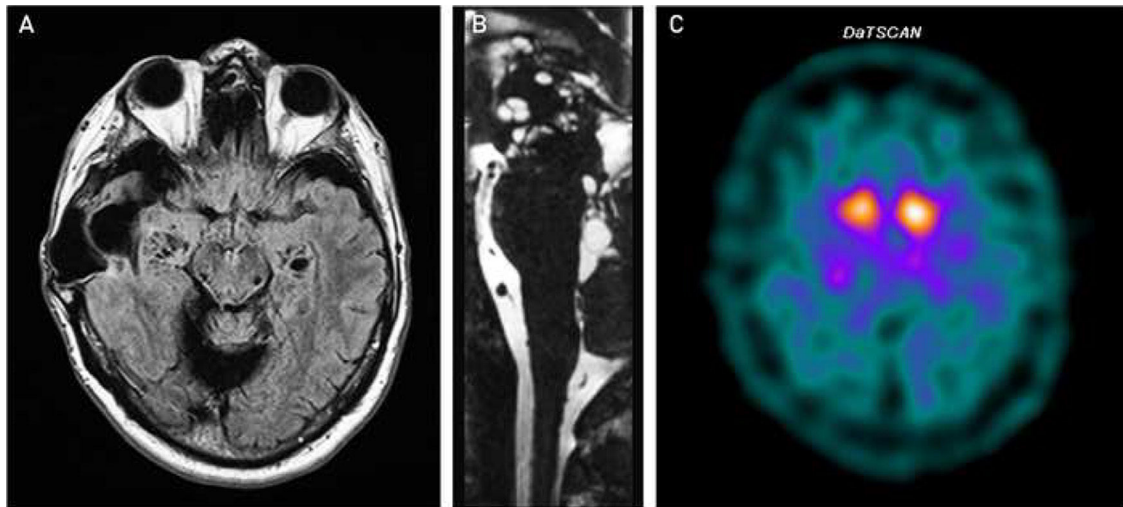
A) Axial FLAIR MRI sequence, showing extensive right temporal encephalomalacia associated with a craniectomy performed due to tuberculous meningitis during childhood, as well as perivascular spaces in the hippocampus, caudal part of the striatum, and bilateral midbrain. B) Sagittal 3D T2-weighted (CISS) MRI sequence, showing cystic lesions in the fourth ventricle and perivascular spaces in the midbrain. C) SPECT study with ioflupane (I-123) (DaTSCAN), showing reduced tracer uptake in the putamen bilaterally.
